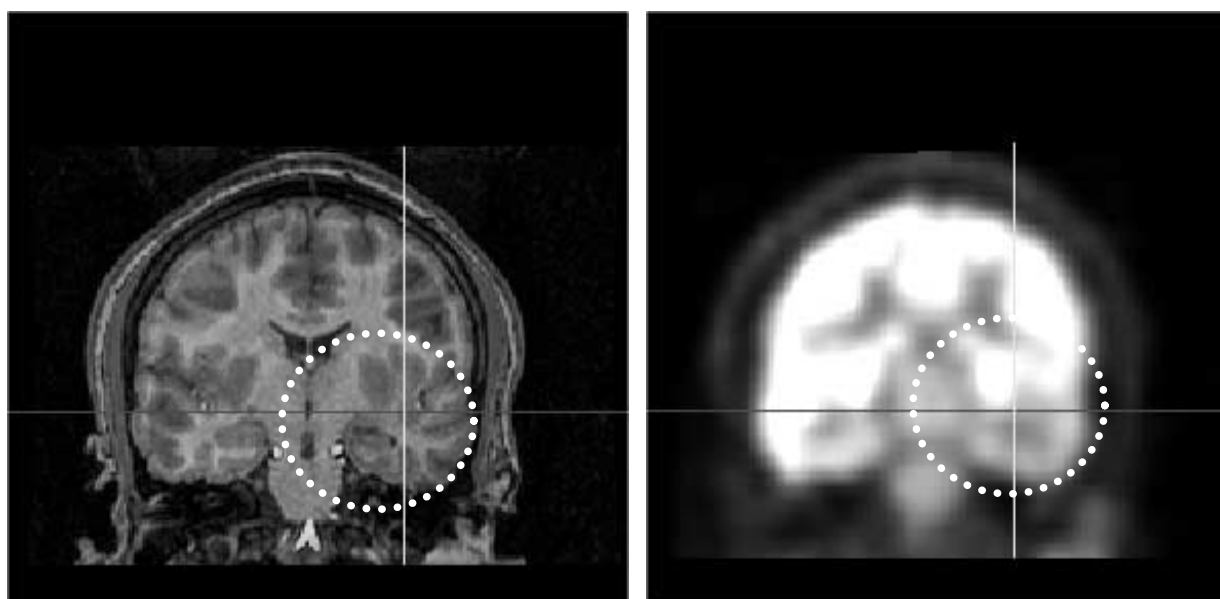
Axes cross on the dipole position provided by BESA and transferred to the MRI and PET. Mesial sclerosis is visible on the MR image (*left*) in the area where the dipole is located. PET asymmetry in that area is also clearly visible (*right*).
